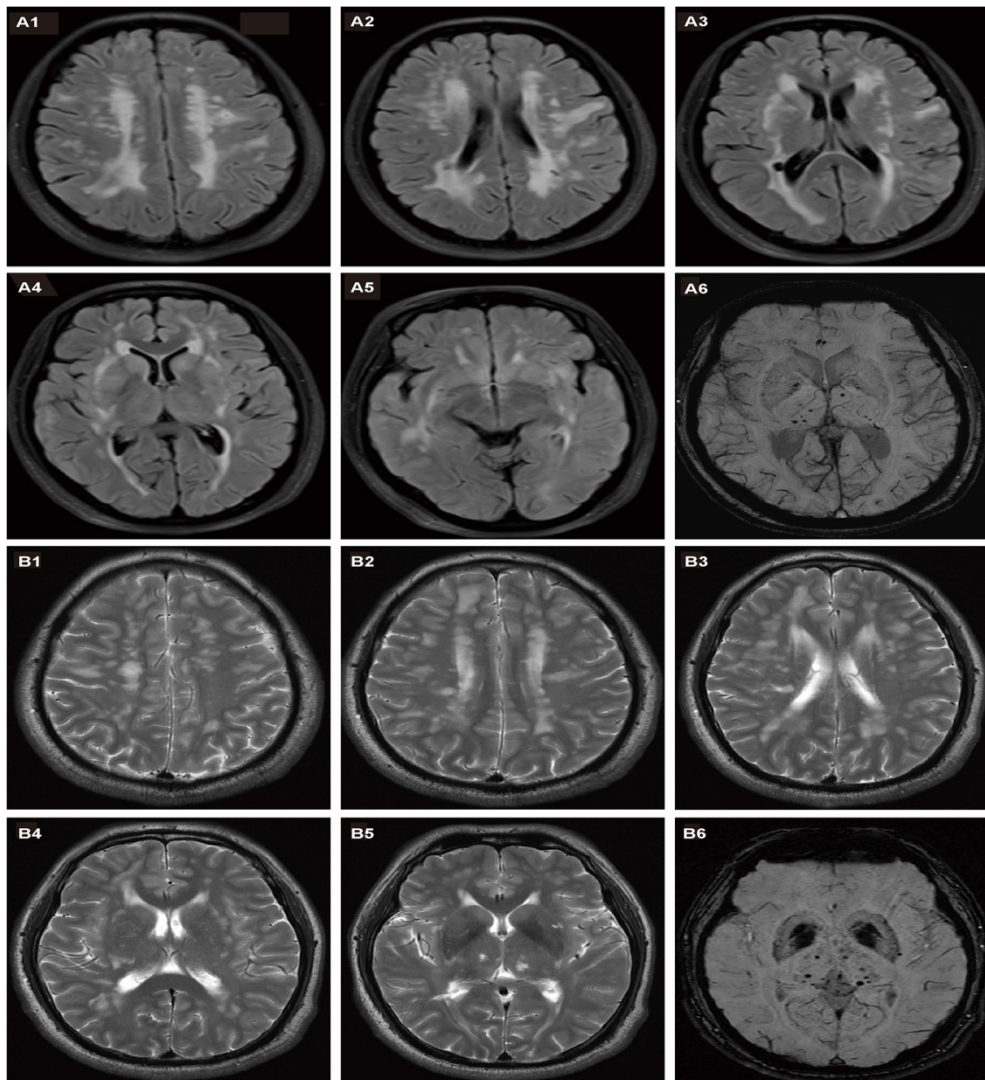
Brain MRI images of the proband (III-9) and her elder brother (III-7).
